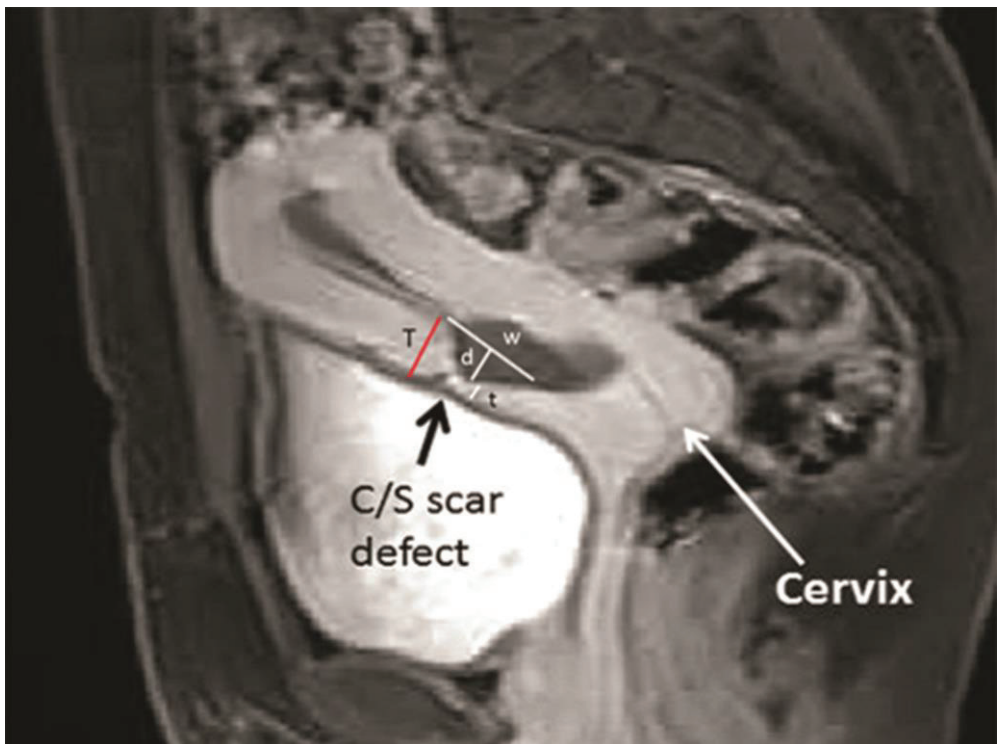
Magnetic resonance imaging measurement of isthmocele: d = depth; w = width; t = residual myometrial thickness; T = adjacent myometrial thickness. Reprinted from *Gynecology and Minimally Invasive Therapy*, Vol. 7, Wong et al. "Magnetic resonance imaging in the evaluation of Cesarean scar defect", pp.104-10. Copyright, with permission from Wolters Kluwer
